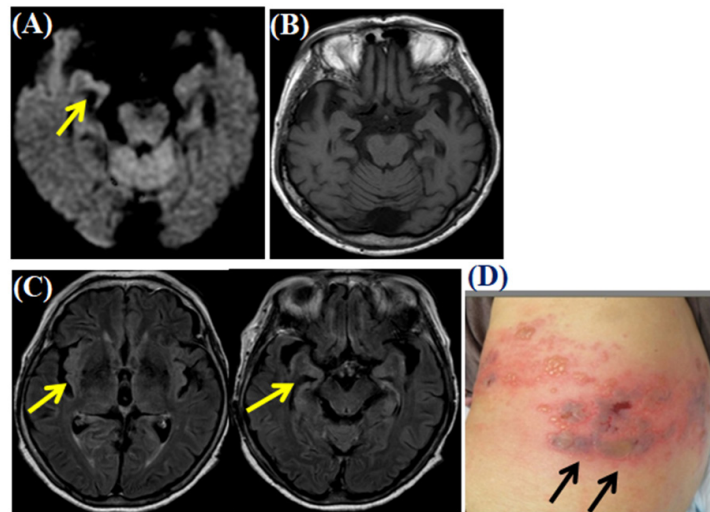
MRI findings of two patients with herpes zoster (HZ) acute limbic encephalitis and HZ skin rash. (A) An 86-year-old female with Alzheimer disease, had acute limbic encephalitis (ALE) with HZ in the first branch of the right trigeminal nerve, and impaired consciousness. This MRI diffusion-weighted image at acute stage showed high-intensity at medial temporal lobe (arrow only on right side). (B) MRI T1 image at recovery stage exhibited atrophy of the bilateral hippocampal regions. The MRI images are reprinted with permission from reference reported by Matsuoka *et al.* (7). (C, D) This 84-year-old female with left thoracic spinal Th11–12 HZ showed fever, and impaired consciousness. Contrast-enhanced fluid attenuated inversion recovery (FLAIR) MRI images showed bilateral medial temporal lobe and insular lobe lesions (arrow only on the right side).
